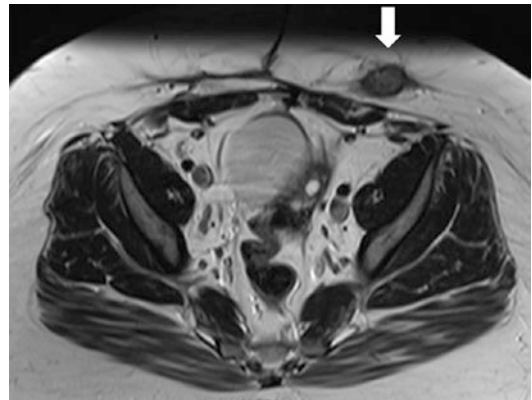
T1-weighted axial image through the same region demonstrates an indeterminate, intermediate signal lesion (arrow) within the subcutaneous operative scar
